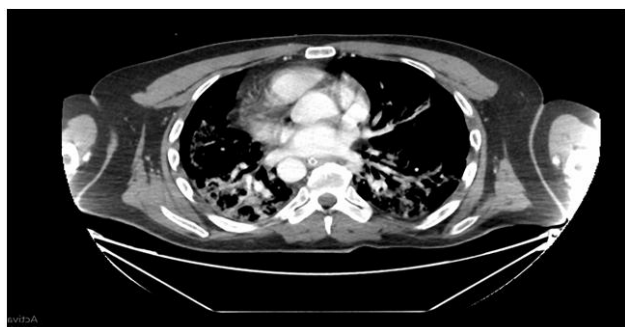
25.08.2020 CT scan of the chest, 3 days after ECMO
